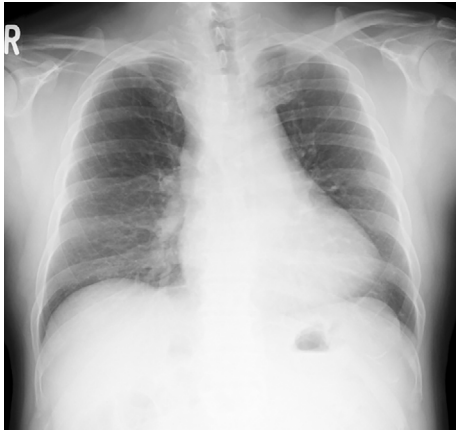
Chest X-ray findings. The widened superior mediastinum is visible on chest X-ray.
